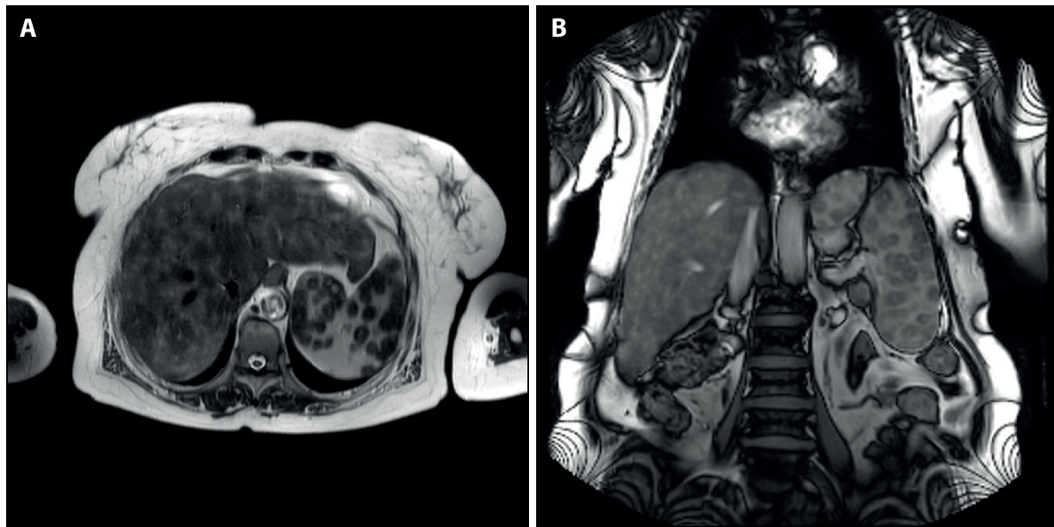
(A) Abdomen MRI. Axial plain. (B) Abdomen MRI. Coronal plain: Diffuse, multiple, nodular hyperintense lesions on T2 weighted, which did not show enhancement in the liver and spleen parenchyma.
